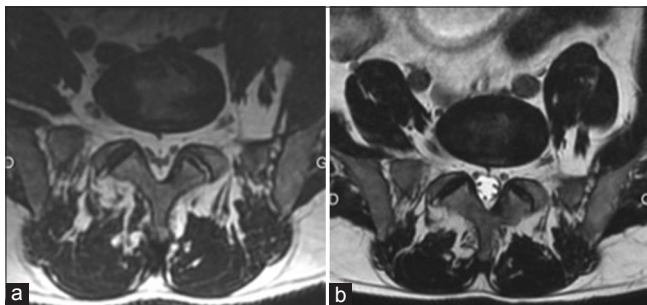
Before (a) and after (b) axial T2 images on magnetic resonance imaging demonstrating epidural lipomatosis after a 16 kg weight loss from March 2018 to December 2018
